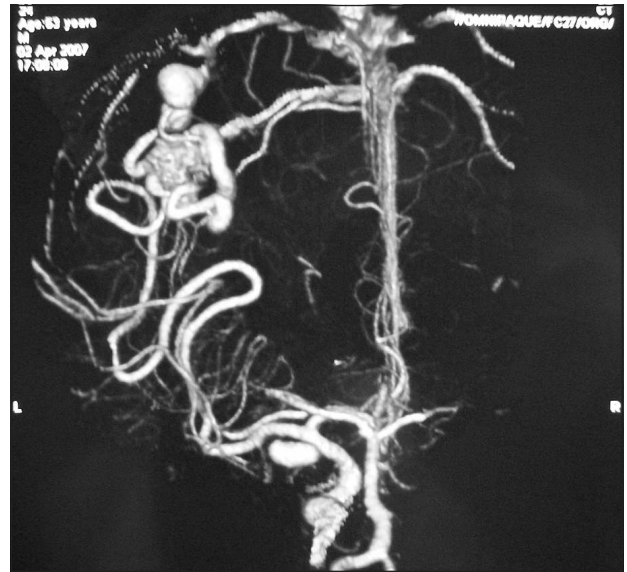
CTA demonstrating high flow AVM in the eloquent motor area and left ICA aneurysm.
